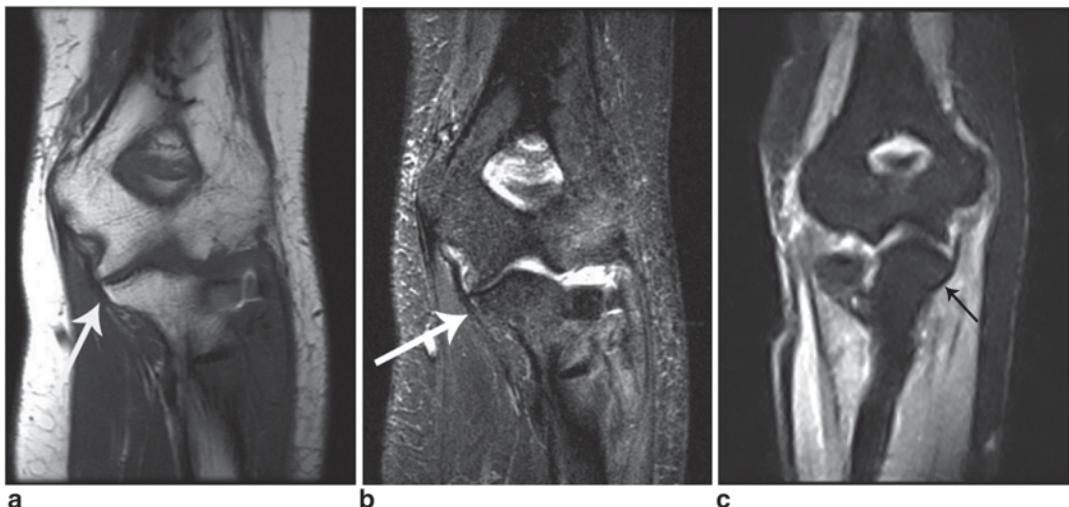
Coronal T1-weighted (a) and coronal short tau inversion recovery (STIR) (b) images show the anterior band of the UCL as a continuous band of low signal intensity extending from the inferior medial epicondyle to
